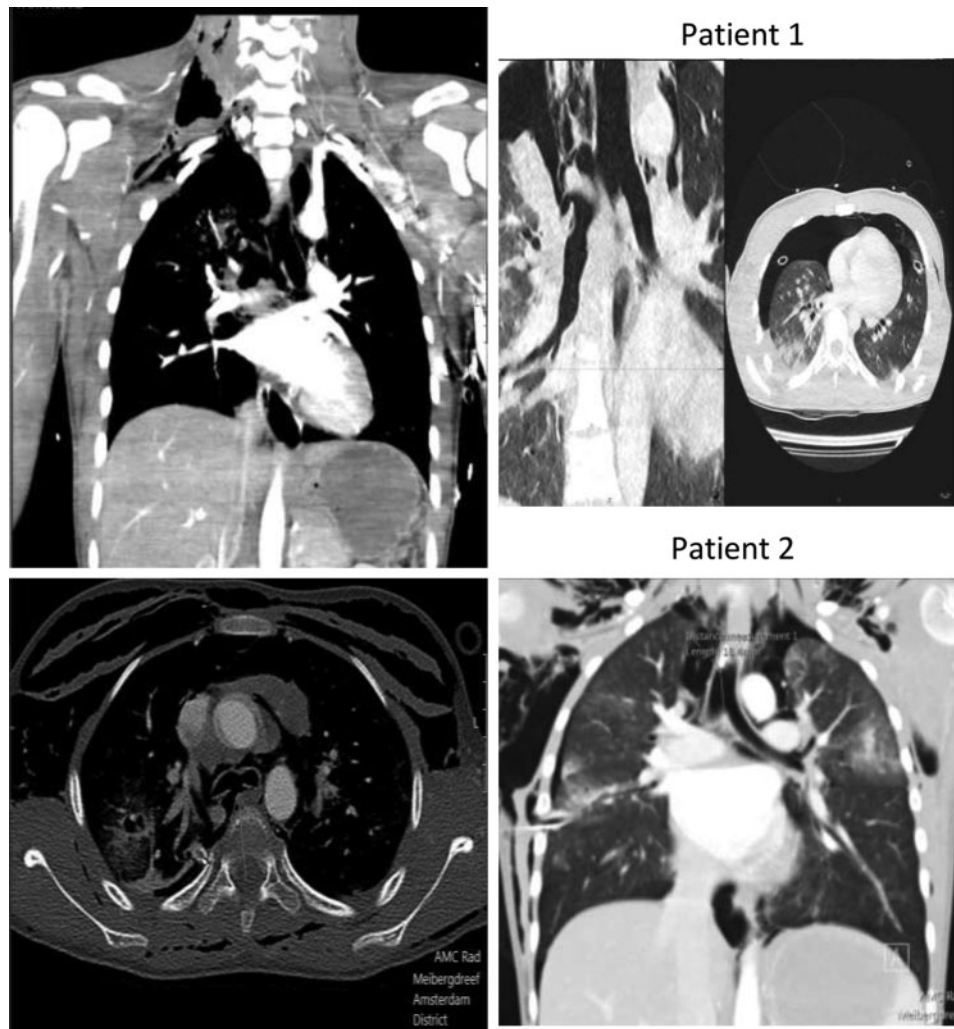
CT scan in the first patient, showing a lack of continuity between trachea and right main bronchus and bilateral lung contusions. CT scan in the second patient, showing an almost complete avulsion of the right main bronchus from the trachea.
